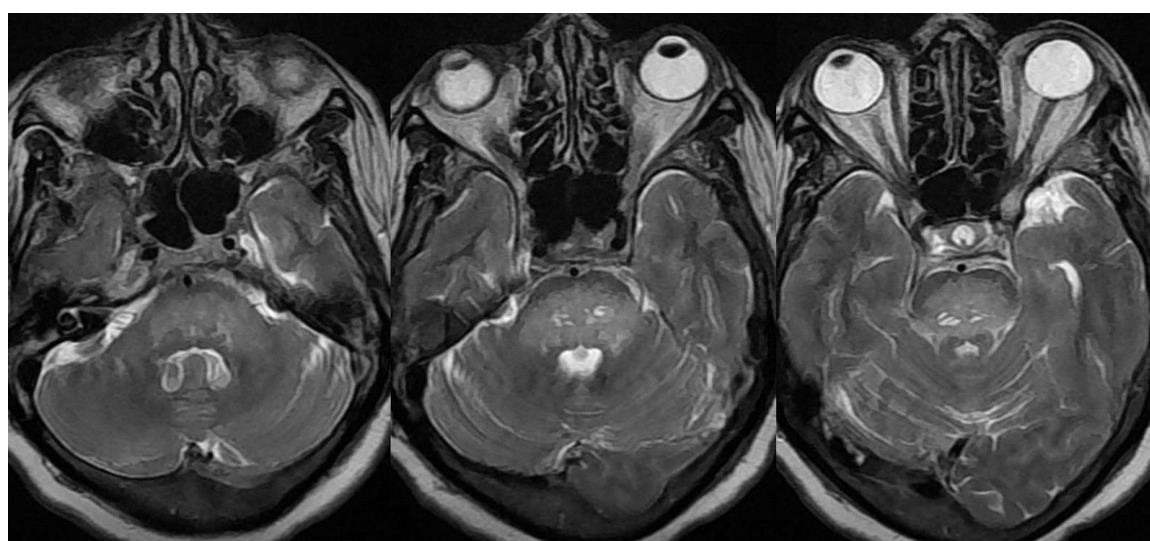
Serial axial T2 weighted MR images (TR=3200 ms, TE=82.9ms) showing hyperintensities in pons
